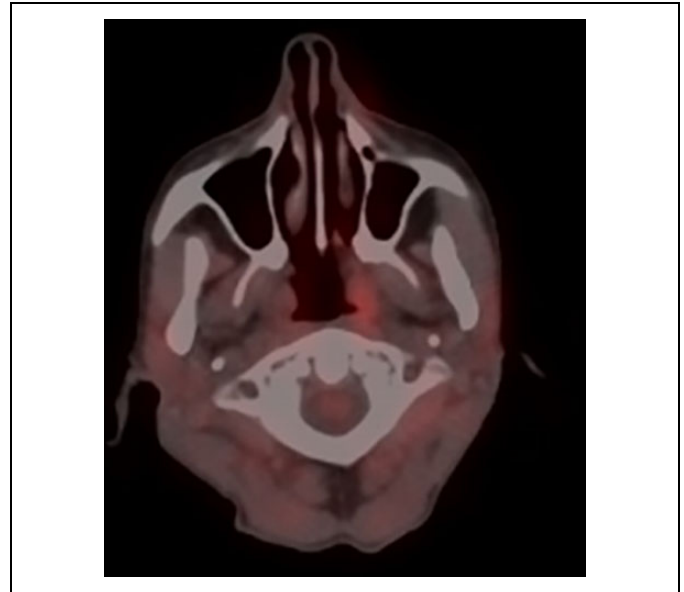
Positron emission tomography–computed tomography (PET/CT) total body after one year by treatment.
